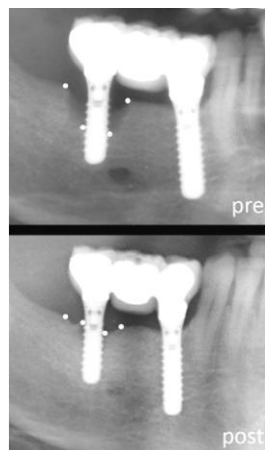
Magnification of a section of panoramic x-rays before (pre) and 12 months after (post) surgical intervention. The points indicate the surrounding bone level, the medial ones the deepest point of the pockets beside the implant.
